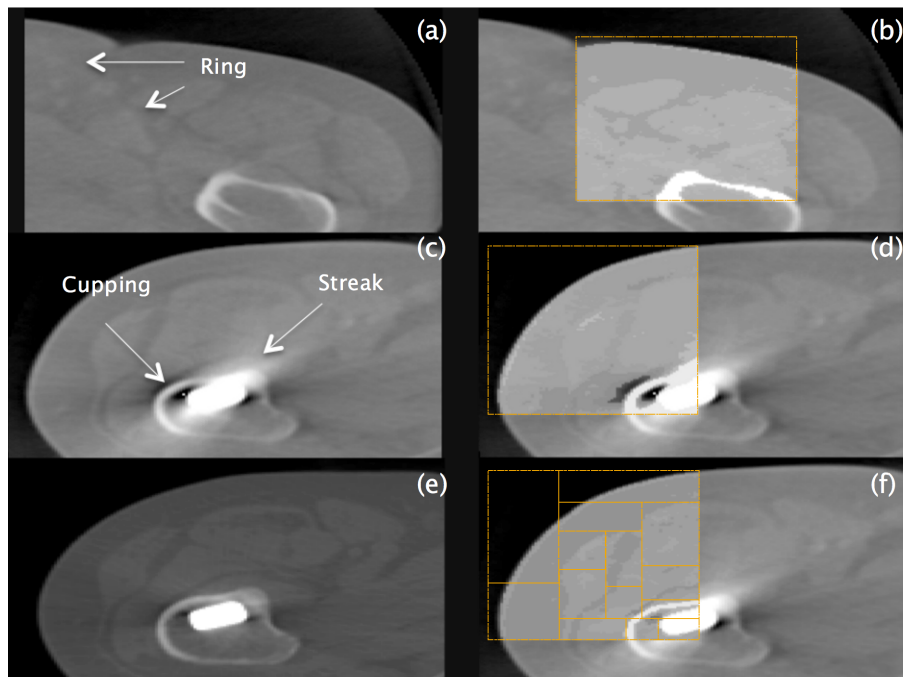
Two different locations and slices of the original CBCT (a and c) and the resultant images after segmentation using the same threshold values in only a part of the image (b and d respectively). In particular it is observed in (d) that the artefacts in the vicinity of the metal are erroneously corrected. Variable threshold values were then used (f) which compared well with the original pCT image (e).
